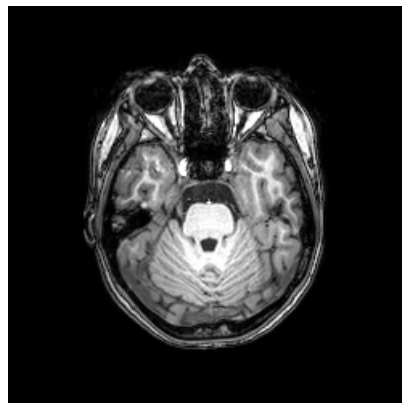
A template MRI of a patient used for the validation of the registration parameters.
